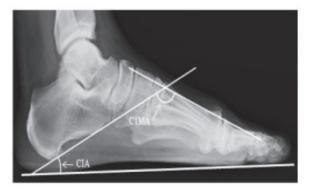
Digital radiograph of left foot in lateral view showing calcaneal inclination angle (CIA) and calcaneal first metatarsal angle (C1MA).
